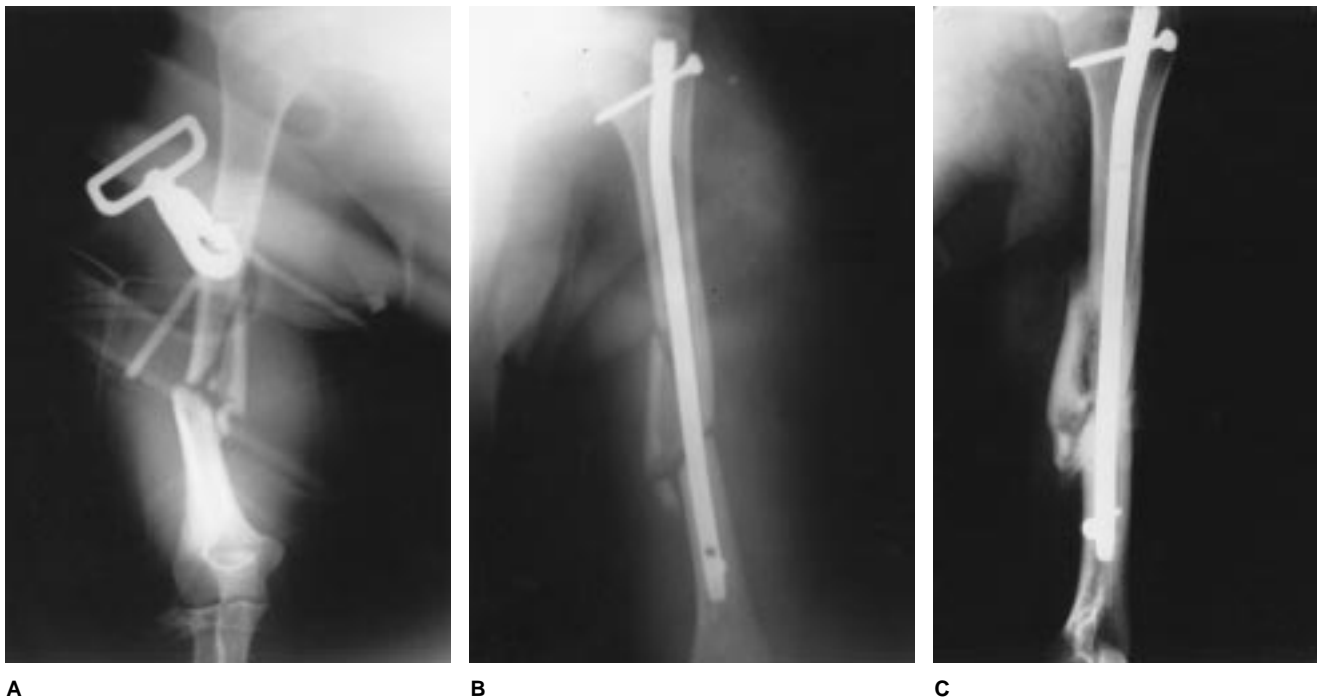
A, Anteroposterior radiograph shows a comminuted humeral fracture in a polytraumatized patient. B, Anteroposterior radiograph after fixation with an antegrade interlocking intramedullary nail. C, Anteroposterior radiograph obtained at 10 months shows complete union of fracture.
